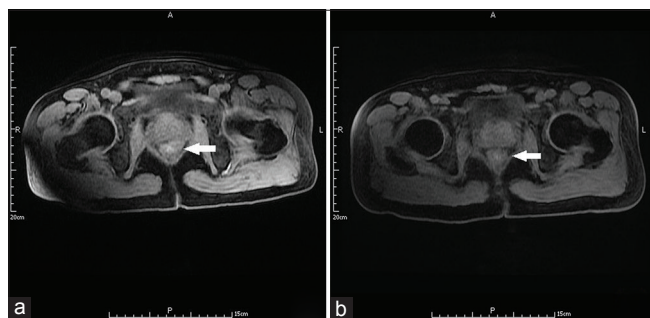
An magnetic resonance imaging of the abdomen showed a nodular lesion about 1.8 cm in size between the rectum and prostate with persistent enhancement during the dynamic study (a); compared with the magnetic resonance imaging taken 1-year earlier, a nodular lesion within the prostate could not be identified at follow-up (b)
